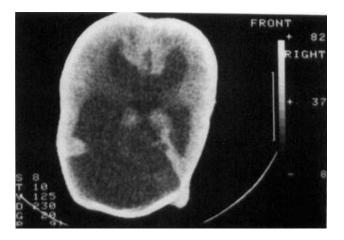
Case 2. CT scan showing thin brain parenchyma and markedly dilated lateral ventricles. The ventricles are connected through a defect in the septum. A large posterior fossa cyst resembling Dandy-Walker anomaly is noted, together with dysgenesis of corpus callosum.
